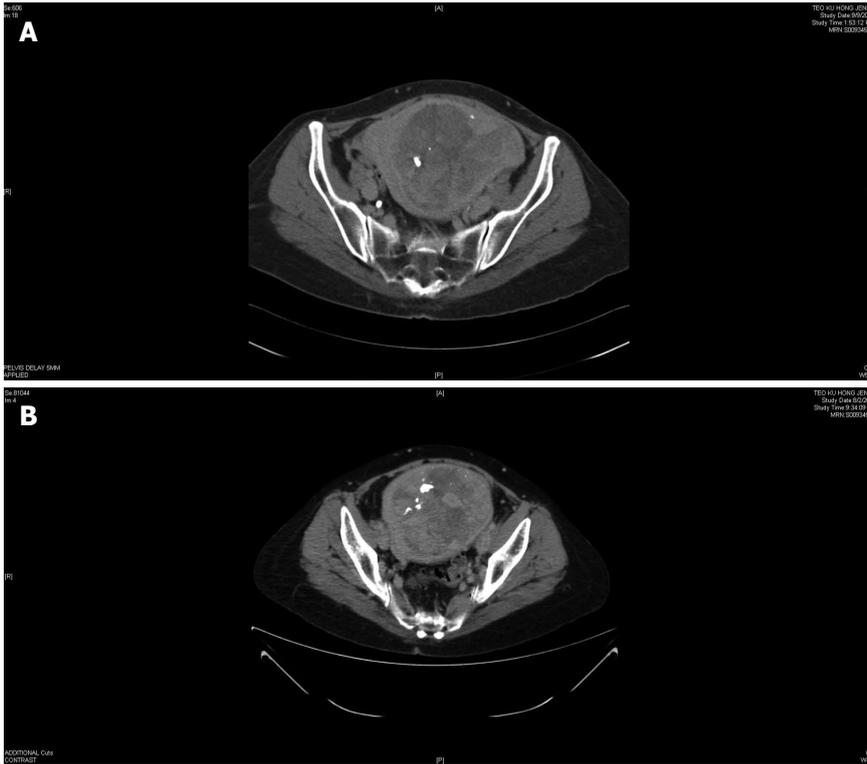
Computed tomography scan of the pelvis showing fibroid uterus. A: August 2008; B: September 2012.
